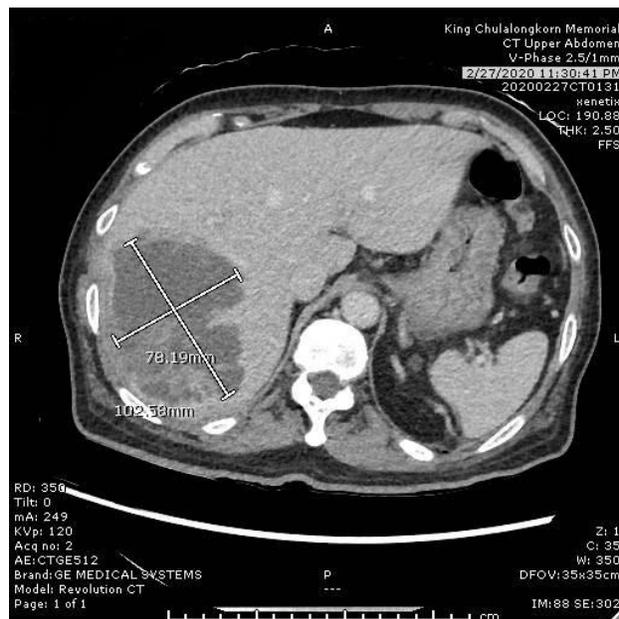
CT upper abdomen showed liquified heterogenous mass 10 x 11 cm at right hepatic lobe with no demonstrable common bile duct (CBD) not intrahepatic duct (IHD) dilatation.
